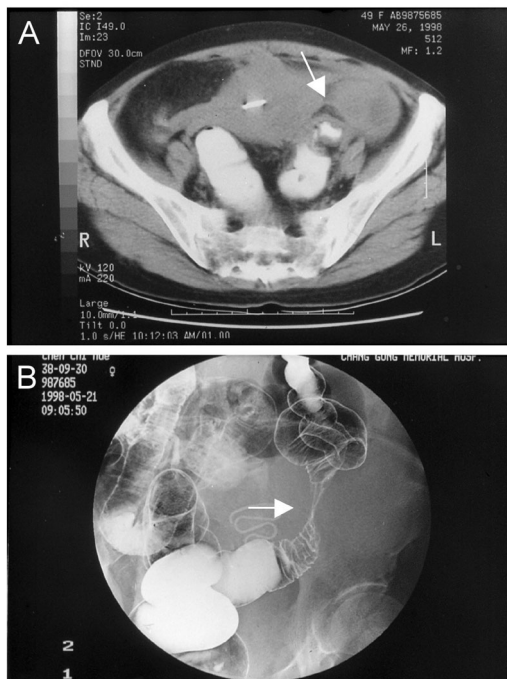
This patient, Case 9, has irregular bowel movement with dull abdominal pain over left low quadrant. A: Mass lesion with lumen stenosis over junction of S-colon and distal D-colon at abdominal CT examination; IUD at uterus; B: Mucosa lesion with luminal stenosis (apple-cord) at barium enema, double contrast examination.
